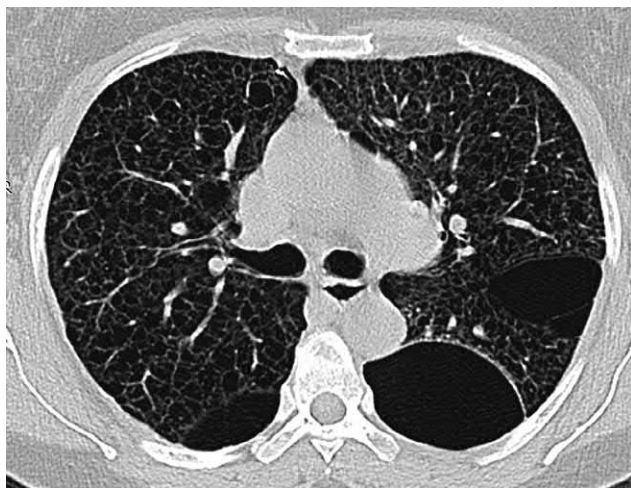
LAM. Axial (A) and coronal (B) scans of the same patient with a normal chest X-ray image. Multiple diffusely distributed thin-walled cysts of small and medium sizes from 2 to 15 mm in diameter inside a normal lung parenchyma.
